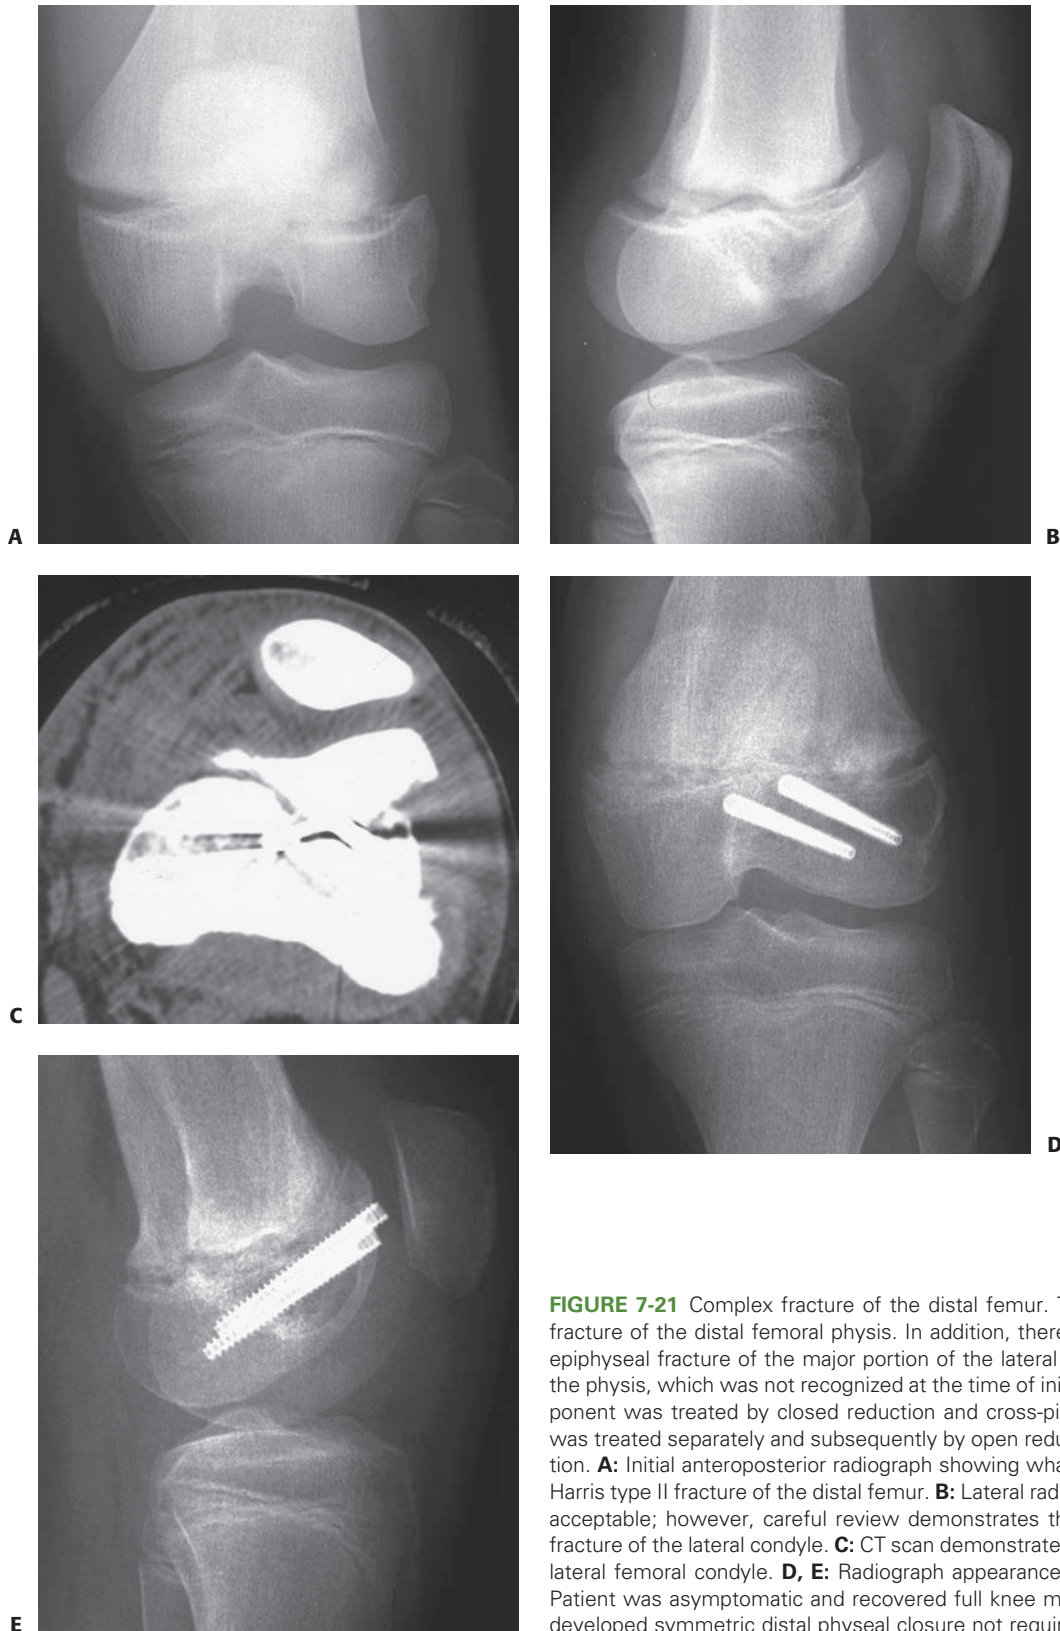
Complex fracture of the distal femur. There is a Salter–Harris type II fracture of the distal femoral physis. In addition, there is an additional coronal plane epiphyseal fracture of the major portion of the lateral femoral condyle, not involving the physis, which was not recognized at the time of initial treatment. The type II component was treated by closed reduction and cross-pinning. The epiphyseal fracture was treated separately and subsequently by open reduction and headless screw fixation. A: Initial anteroposterior radiograph showing what appears to be simple Salter–Harris type II fracture of the distal femur. B: Lateral radiograph after reduction appears acceptable; however, careful review demonstrates the coronal plane, intra-articular fracture of the lateral condyle. C: CT scan demonstrates the epiphyseal fracture of the lateral femoral condyle. D, E: Radiograph appearance after healing of the fractures. Patient was asymptomatic and recovered full knee motion. In follow-up, the patient developed symmetric distal physeal closure not requiring further treatment.
